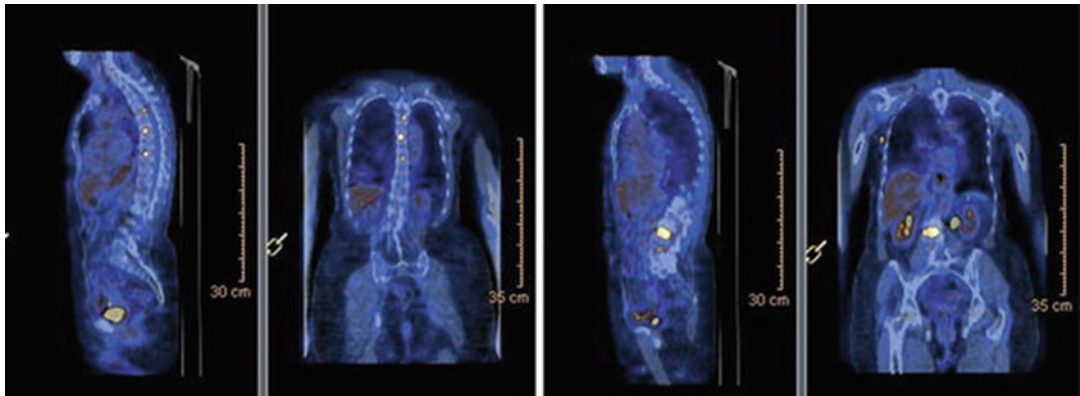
Fused coronal and sagittal PET/CT images showing metastatic bone involvement of dorsal (left panel) and lumbar (right panel) spine
